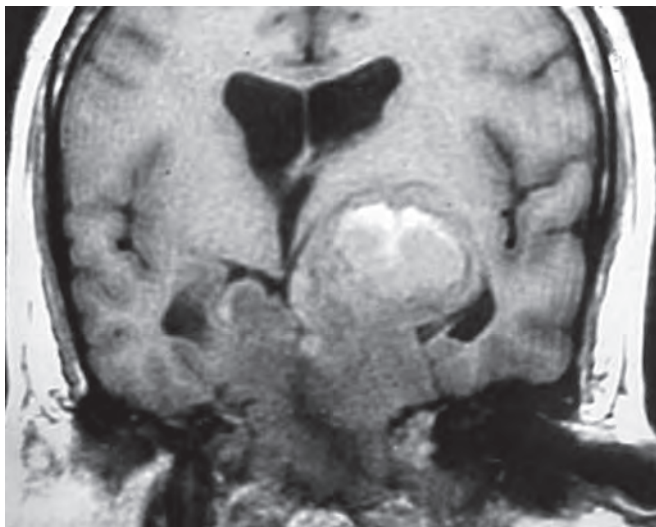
MRI coronal sections of the same patient as in Figure 1 showing evidence of apoplexy
